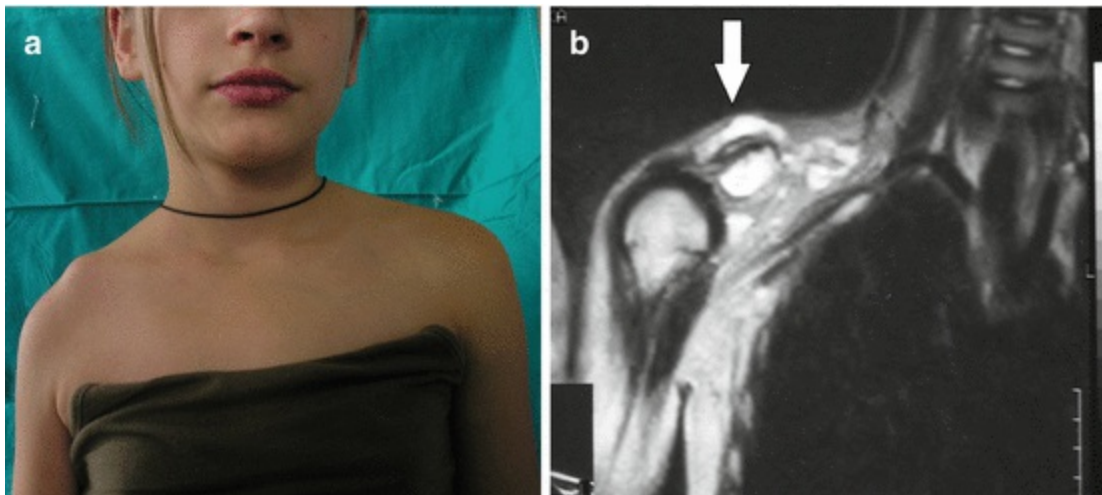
Gorham syndrome: (a) deformation of the right shoulder area; (b) magnetic resonance imaging revealing presence of lymphatic malformation
